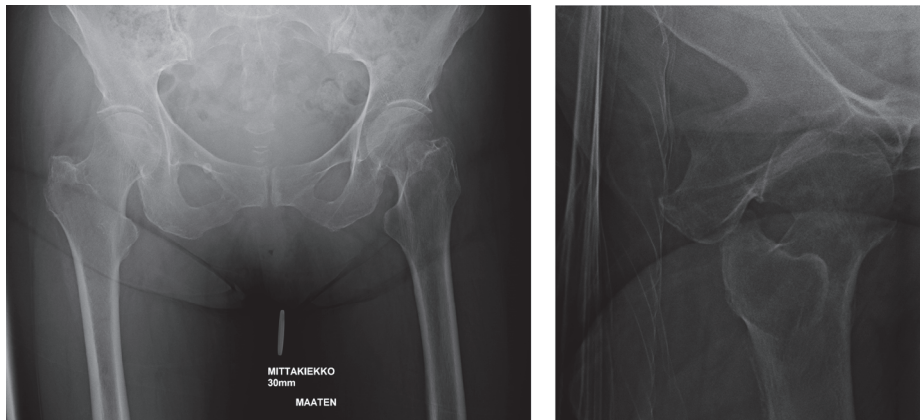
X-ray image of femoral neck fracture.
